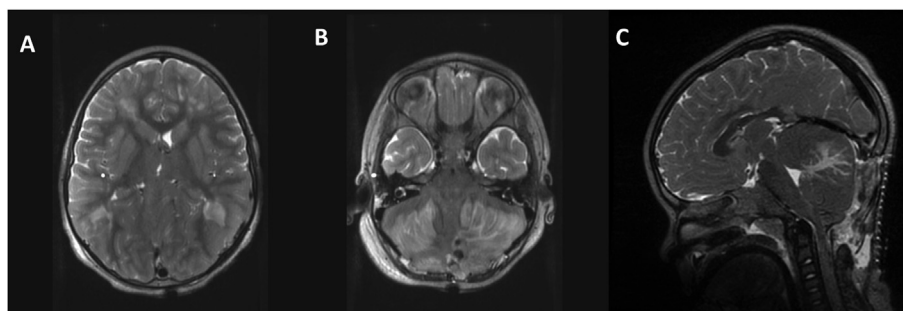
Post-operative MRI 2 days after presentation at the time of persistently high ICP. A) Axial T2-weighted image showing decompression of the ventricular CSF, B) Axial T2-weighted image and C) Sagittal T2-weighted image showing persistent compression of the brainstem.
